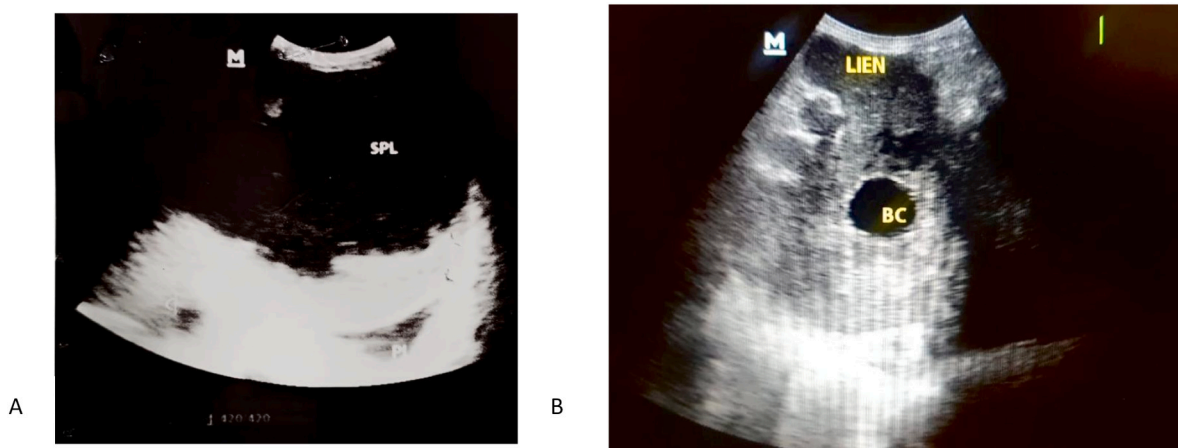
A) The ultrasound of the spleen revealed hypoechoic lesion suggestive of splenic abscess B) Ultrasound of the spleen post-operatively shows resolution of the splenic abscess (LIEN) and the catheter balloon (BC) in situ.
